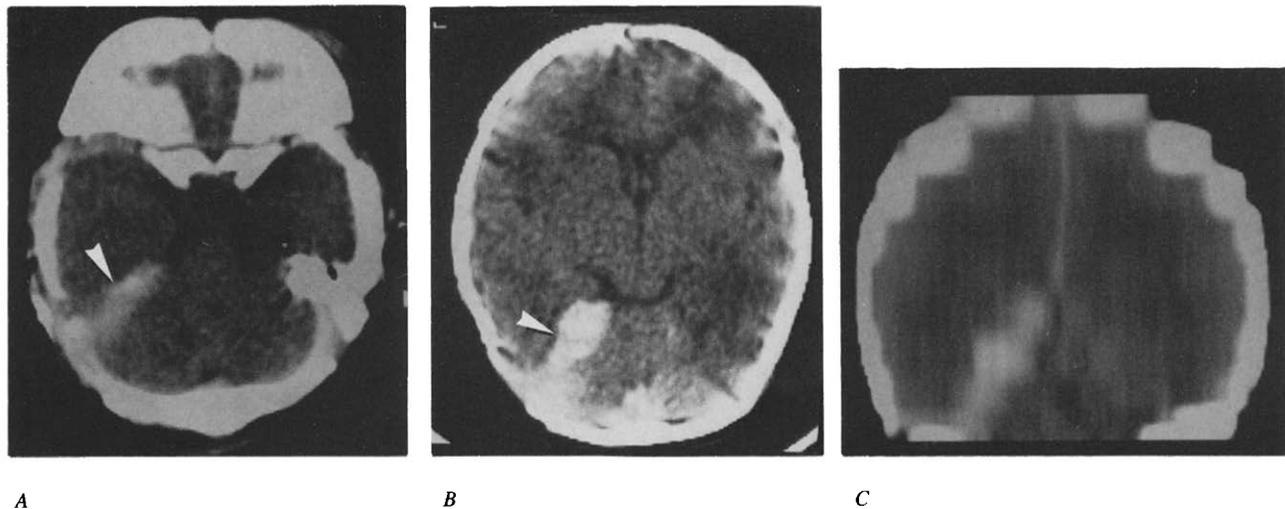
CT of the subdural hemorrhage at the tentorial leaflet in Patient 2. (A) Hemorrhage at the tentorial petrous attachment (arrowhead). (B) Bleeding at the tentorial leaflet (arrowhead). (C) Coronal reconstruction view demonstrating hemorrhage along the tentorial leaflet.
